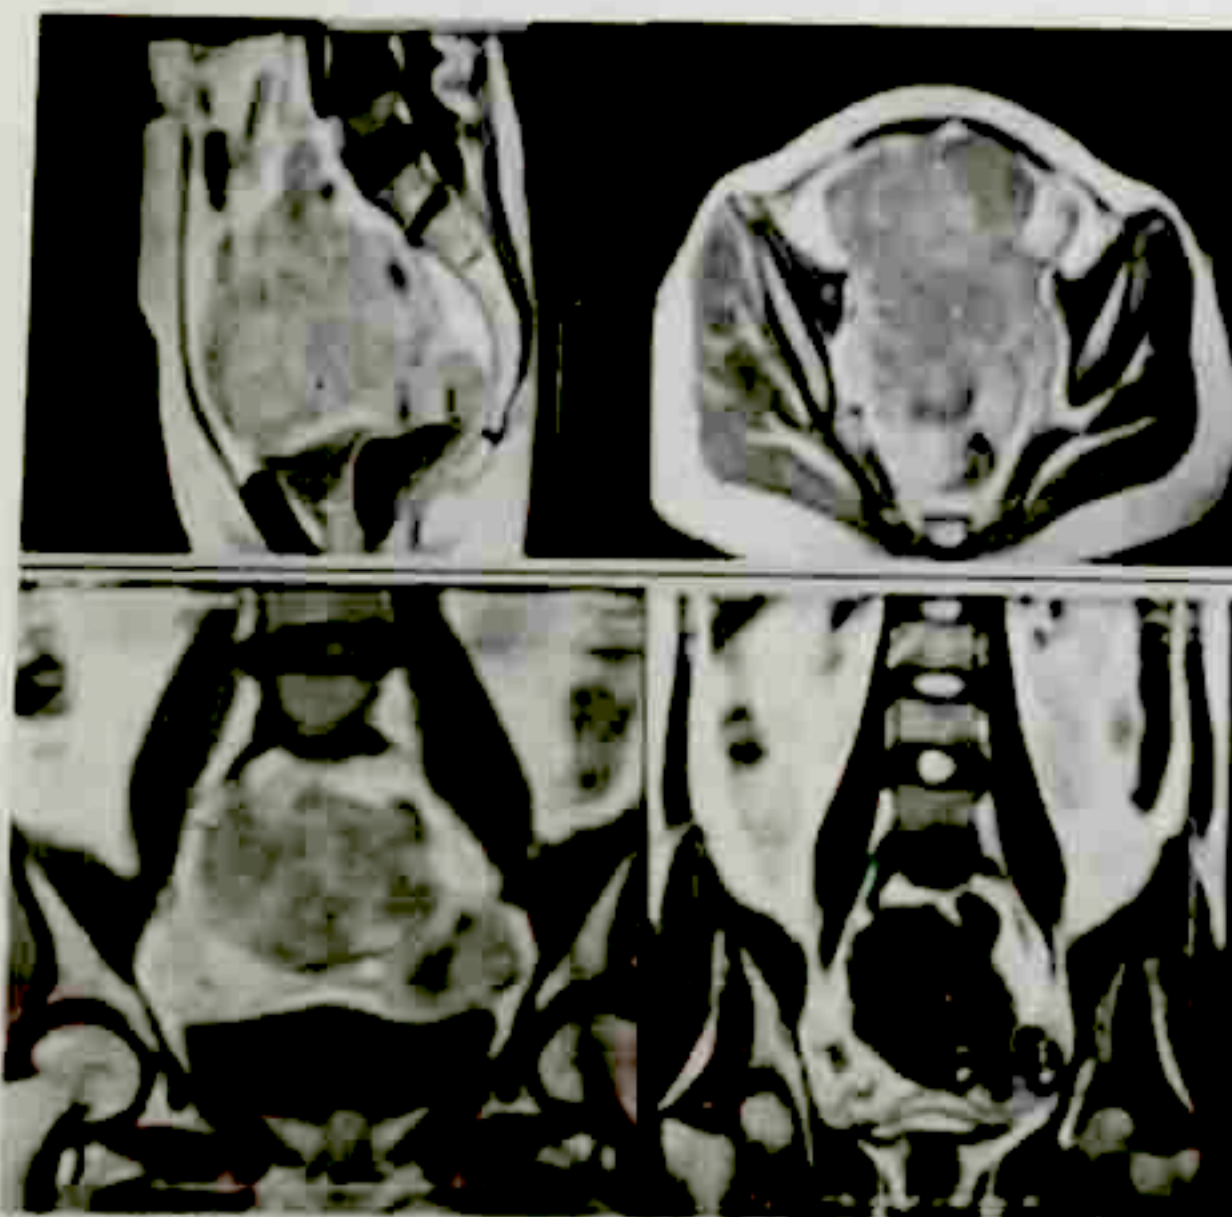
Magnetic Resonance Imaging (MRI) showing the large mass with mixed abnormal intensities and heterogenous enhancement on contrast study.
